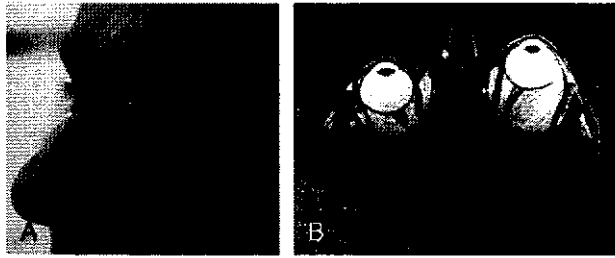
Photograph showing exophthalmos and magnetic resonance imaging showing the intraconal mass.
